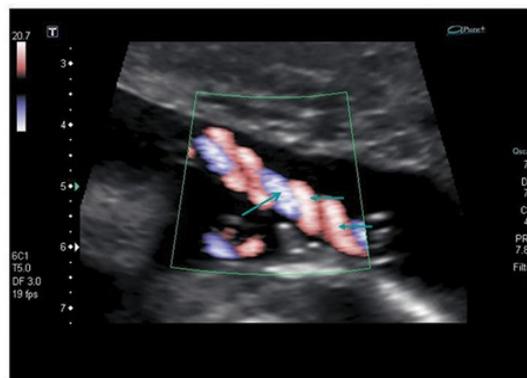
Ultrasound appearance of a normal umbilical cord (Qin et al., 2002)
